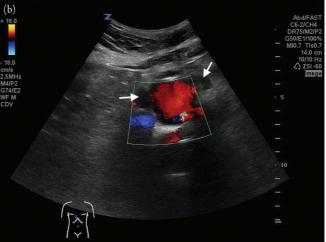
(a) Short axis view of aorta with periaortic lymph nodes. (b) Short axis view of aorta with color Doppler and periaortic lymph nodes. Arrows point to periaortic lymph nodes.
